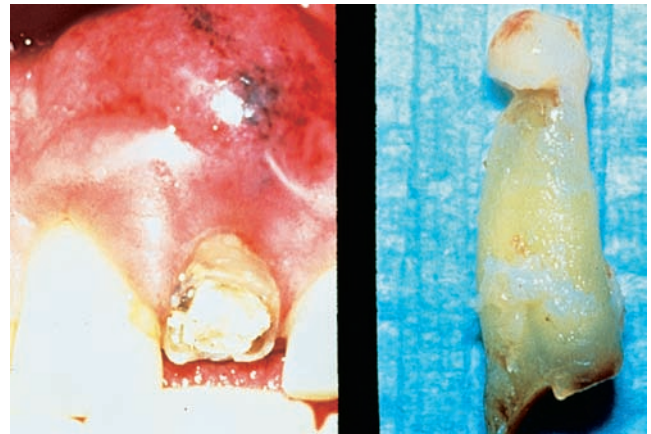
Periapical inflammation: granuloma at apex.
